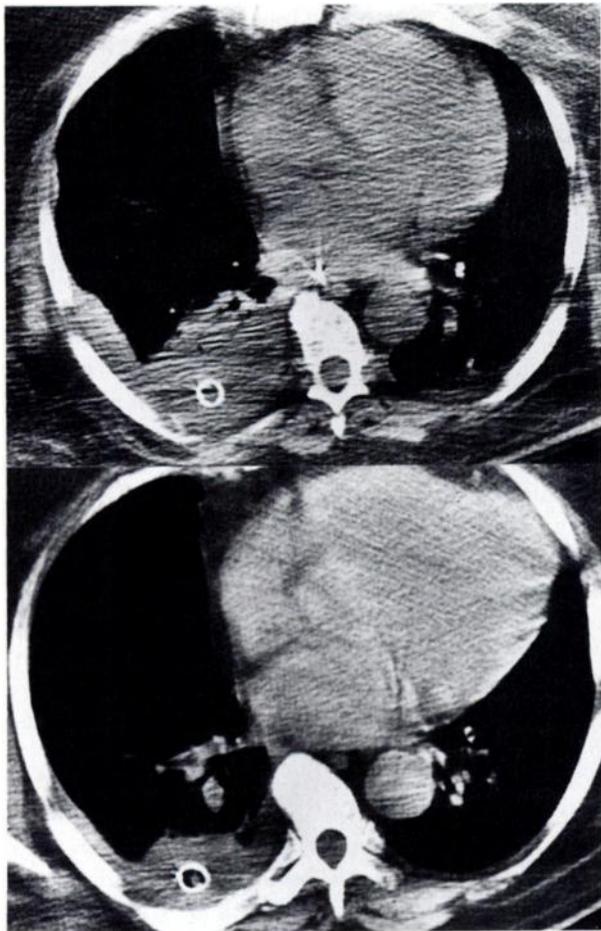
Top.* CT scan of a postoperative empyema 15 days after decortication and rib resection for a 3-month-old infected pleural space. Three days later, UK was instilled through the appropriately positioned chest tube. *Bottom.* CT scan after UK therapy shows only residual pleural thickening.
